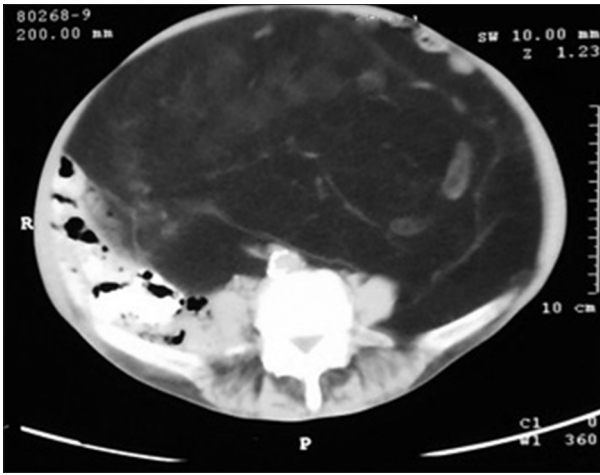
Contrast-enhanced computed tomography abdomen image
